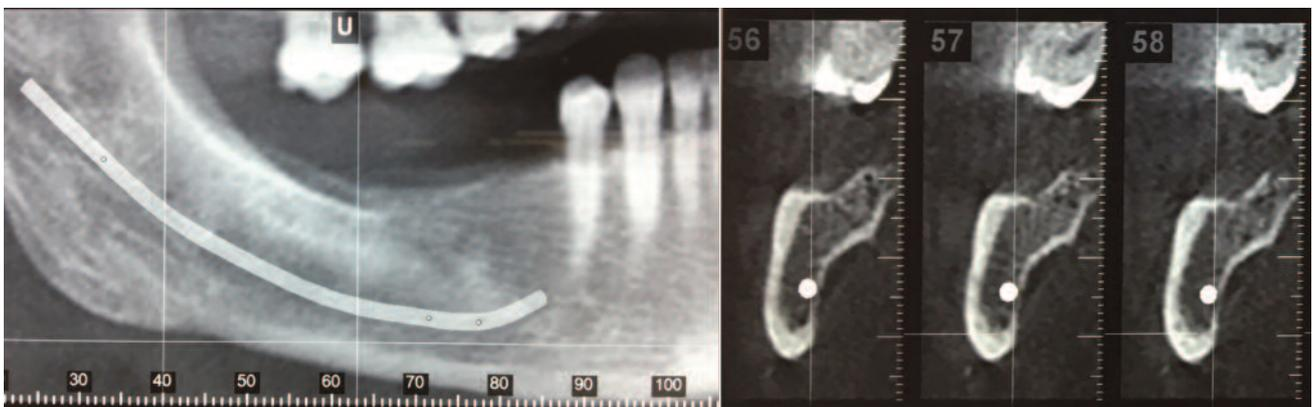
Mandibular CT. Image from the left, frontal slice. Image from the right, sagittal slice. We observe some bone rarification, radiodense and radiotransparent areas.
